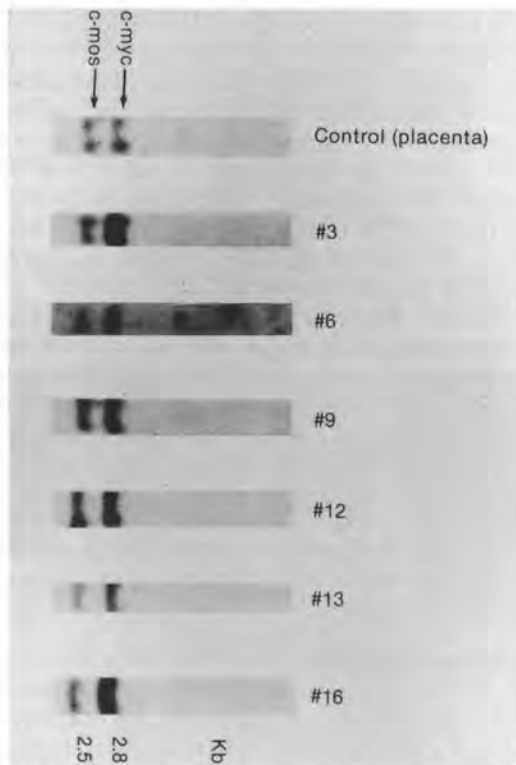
Amplification of *c-myc* in 6 cases of ovarian carcinoma. Lanes are from an autoradiograph of a Southern blot of Hind III-digested DNA from normal placenta and 6 ovarian carcinomas. The intensity of signal of *c-myc* relative to that for the placental control DNA indicates amplification of the *c-myc* oncogene in the tumors. (Sasano H, Garrett CT, Wilkinson DS et al: Proto-oncogene amplification and tumor ploidy in human ovarian neoplasms. *Hum Pathol* 21:382-391, 1990)
